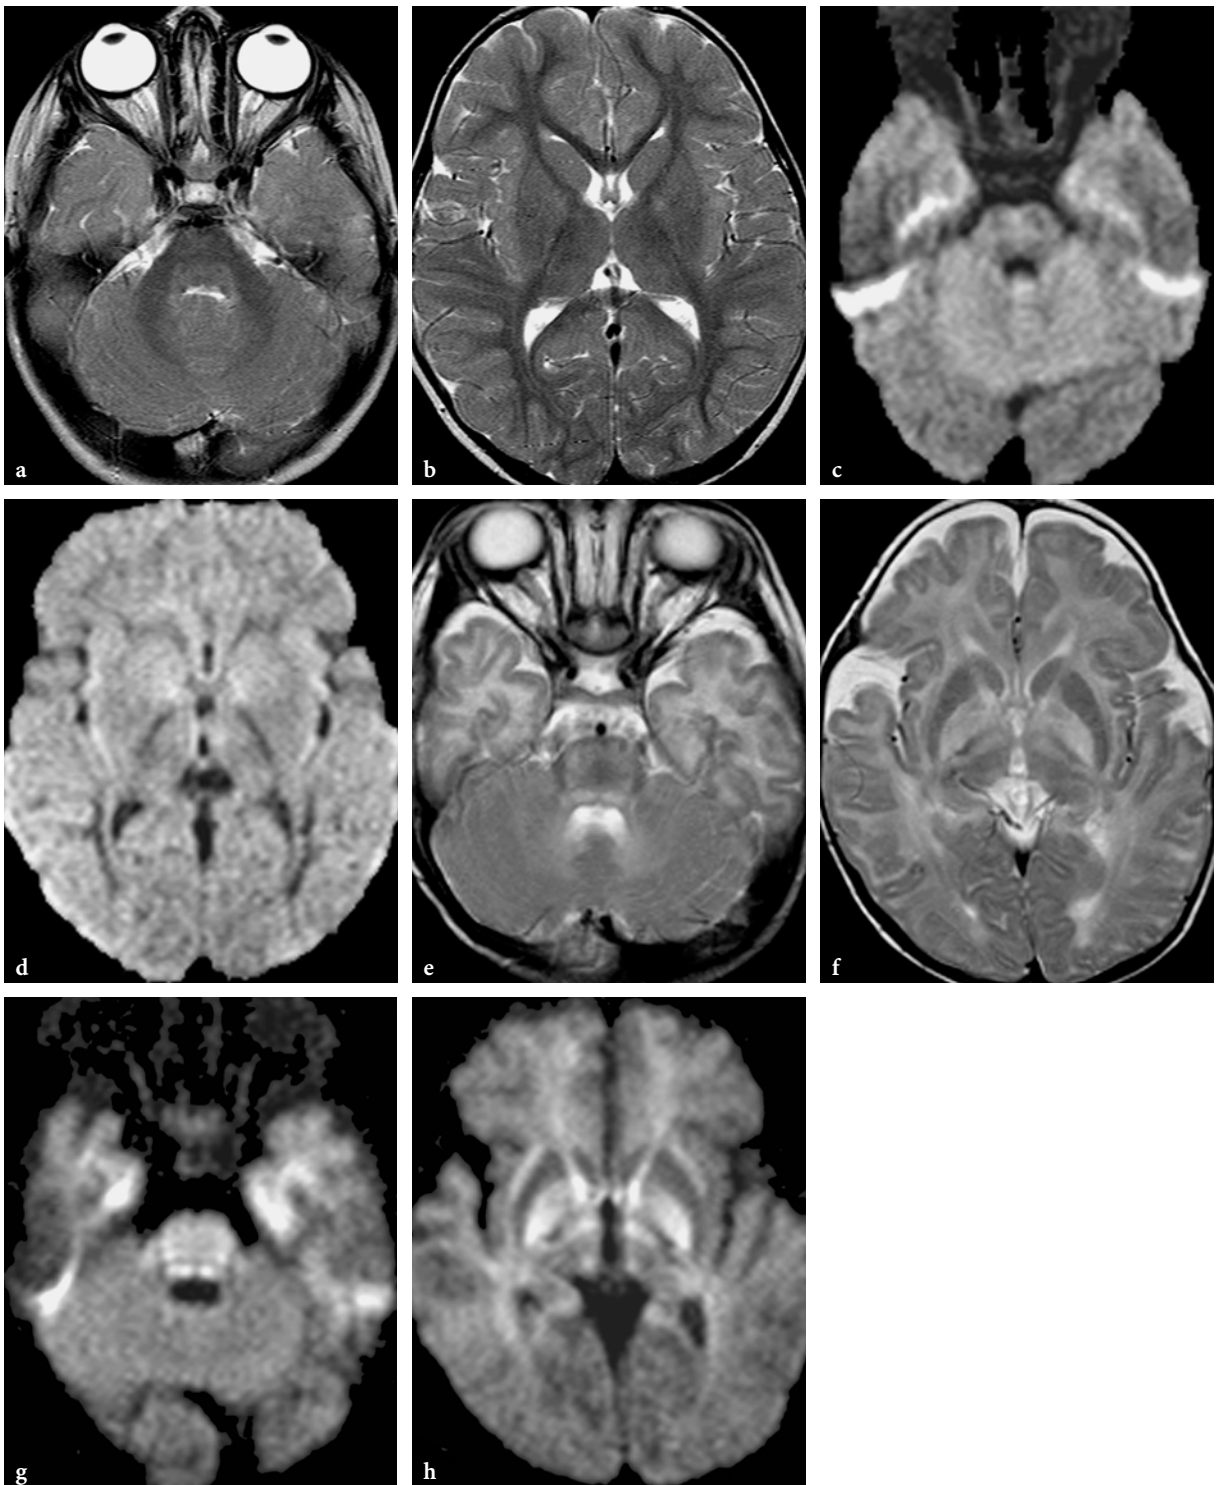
Follow-up MR imaging findings in patients with treated maple syrup urine disease. a-d Axial T2-weighted fast spin-echo (a, b) and diffusion-weighted echo-planar (c, d) images in a 2.5-year-old female patient. Rather unremarkable residual abnormalities are seen, notably faint hypersignal within the tegmentum of the pons, at the level of the globi pallidi, and within subsinular white matter structures. On diffusion-weighted images, very subtle hypersignal is suggested within the globi pallidi. e-h Axial T2-weighted fast spin-echo (e, f) and diffusion-weighted echo-planar (g, h) images in a 14-month-old female patient who had late diagnosis and delayed treatment. Prominent residual signal changes are seen on both conventional and diffusion-weighted images within the brainstem, thalami, and globi pallidi. Very severely delayed overall myelination
